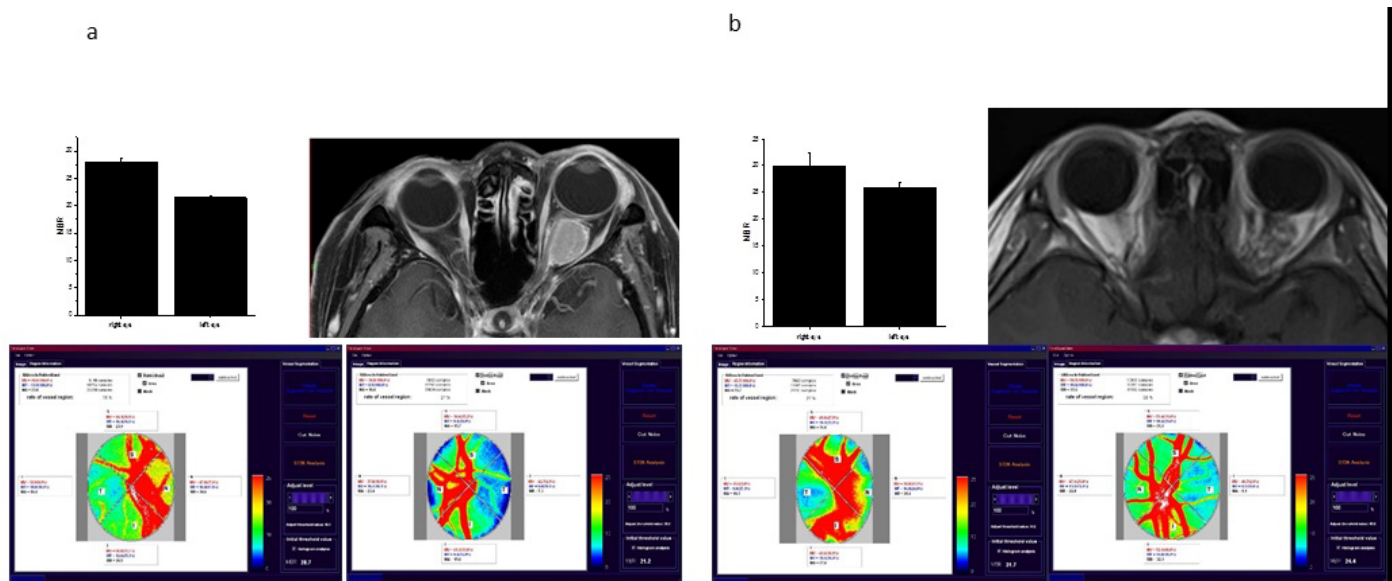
a) Case 1: Mean MBR: right eye; 28.0 ± 0.59 , left eye; 21.5 ± 0.38 (top left). Orbital MRI (top right). Representative LSFG of the right (bottom left), and left eye (bottom right). (b) Case 2: Mean MBR: right eye; 30.0 ± 0.21 , left eye; 16.2 ± 1.17 (top left). Orbital MRI (top right). Representative LSFG of the right (bottom left), and left eye (bottom right).
